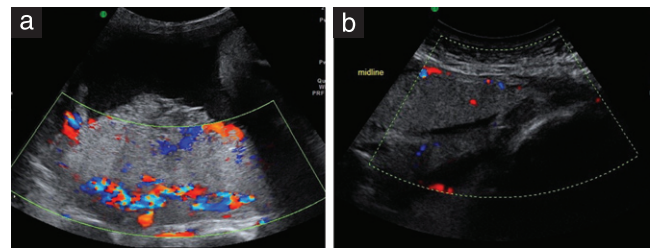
Subplacental hypervascularity (a) and a normal example for comparison (b) on color Doppler imaging.
